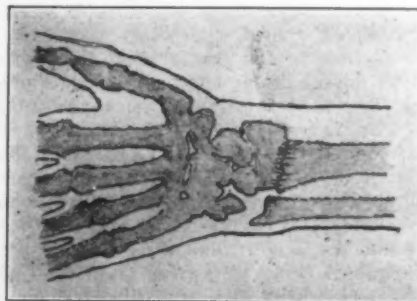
X-Ray tracing of Colles' fracture.
